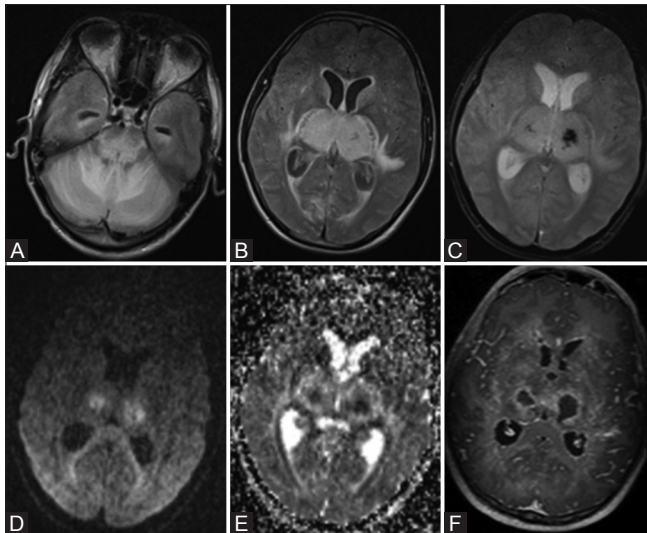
(A-F): Axial FLAIR images show bilateral symmetrical hyperintensities in thalami, pons, bilateral temporal lobe and cerebellum (A and B). GRE image shows loss of signal in bilateral thalamus (C). DWI and ADC images show restriction on diffusion in bilateral thalamus (D and E). Post contrast image shows peripheral enhancement in bilateral thalami (F)
